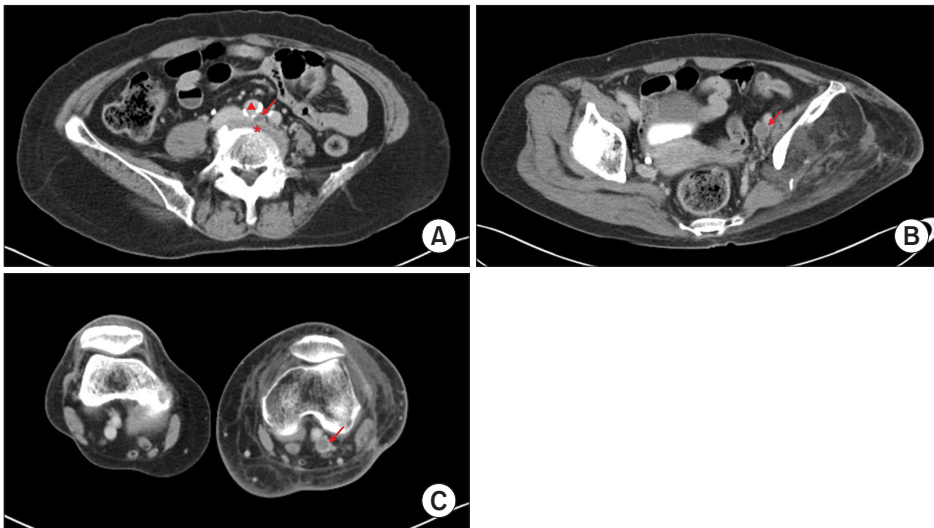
(A) Computed tomography (CT) angiography showed the compression of the left common iliac vein (arrow) between the right common iliac artery (arrowhead) and fifth lumbar vertebral body (asterisk). (B) CT angiography showing thrombosis of the femoral vein (arrow). (C) CT angiography showing thrombosis of the popliteal vein (arrow).
